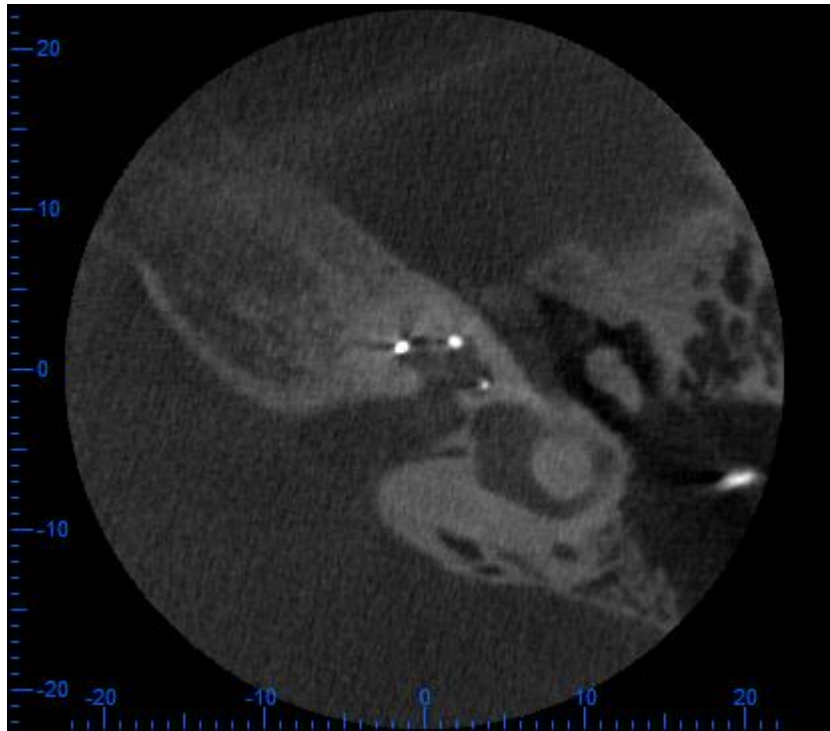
CBCT mid-modiolar reconstruction (axial-view) showing the position of MED-EL™ SONATA<sub>n</sub><sup>100</sup> electrodes in scala tympani. Low metallic artefacts allow estimation of scalar placement of the individual electrodes.
